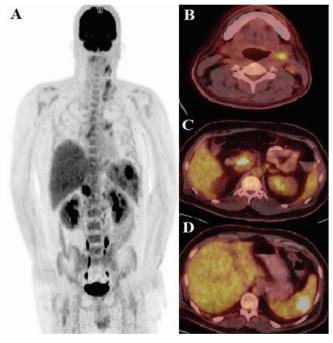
¹⁸F-FDG PET/CT maximum intense projection images (A) and transaxial fusion PET/CT images showed intense uptake of supradiaphragmatic (B), infra-diaphragmatic (C) lymph nodes, and splenic nodal lesions (D) with increased ¹⁸F-FDG uptake
